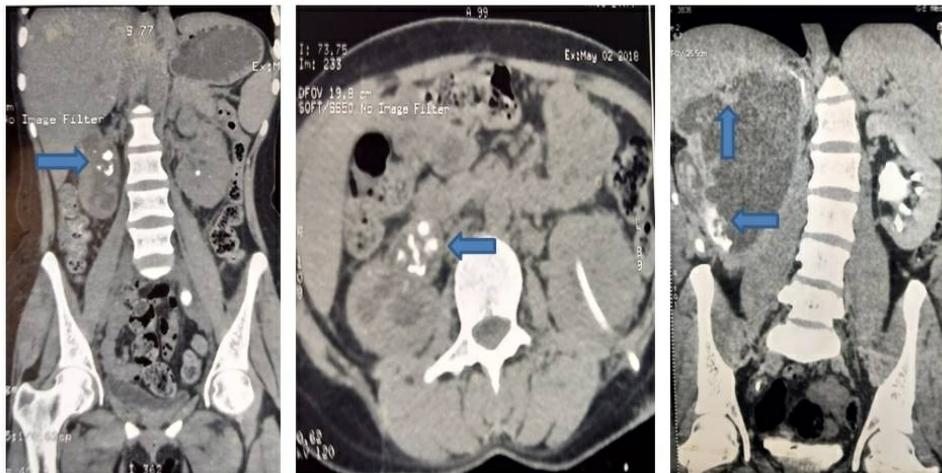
Non contrast CT scan image showing irregular radio-densities in right upper ureter (blue arrow)
